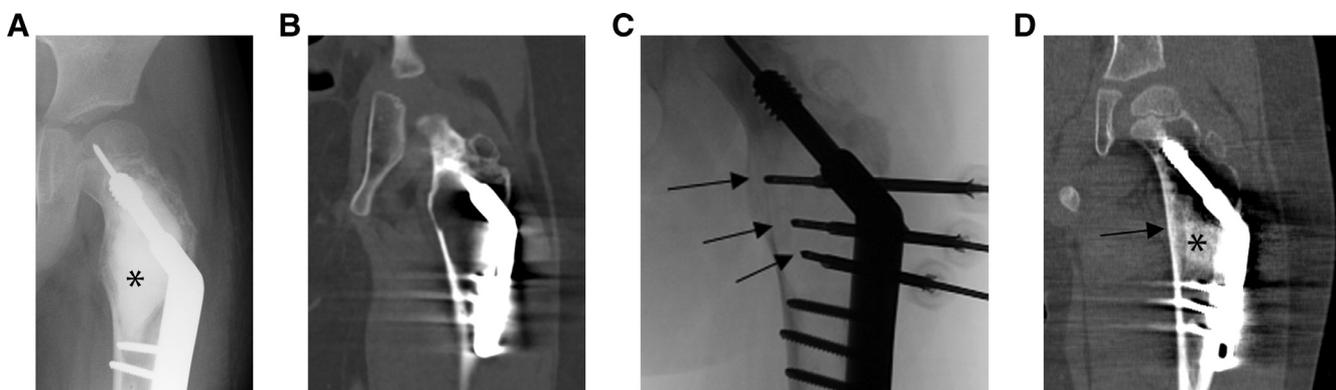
An 8-year-old boy initially presenting to ED with pathologic fracture of the left femoral neck, treated initially with open curettage, reduction and fixation with cementoplasty of the cystic component. An AP radiograph (A) demonstrates the left hip hardware and sequelae of cementoplasty (asterisk). Coronal CT image (B) several years after initial treatment because of a second pathologic fracture and cyst recurrence. Intraoperative fluoroscopic image (C) showing 3 cryoprobes (black arrows) placed within the cyst. A postprocedural coronal CT image (D) demonstrates new sclerosis of the cyst (asterisk) and thickening of the cortex (black arrow). AP, anteroposterior; ED, emergency department.
